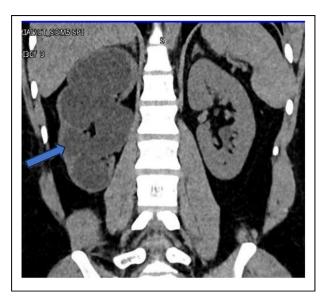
CT showing sever right side hydronephrosis (blue arrow).
